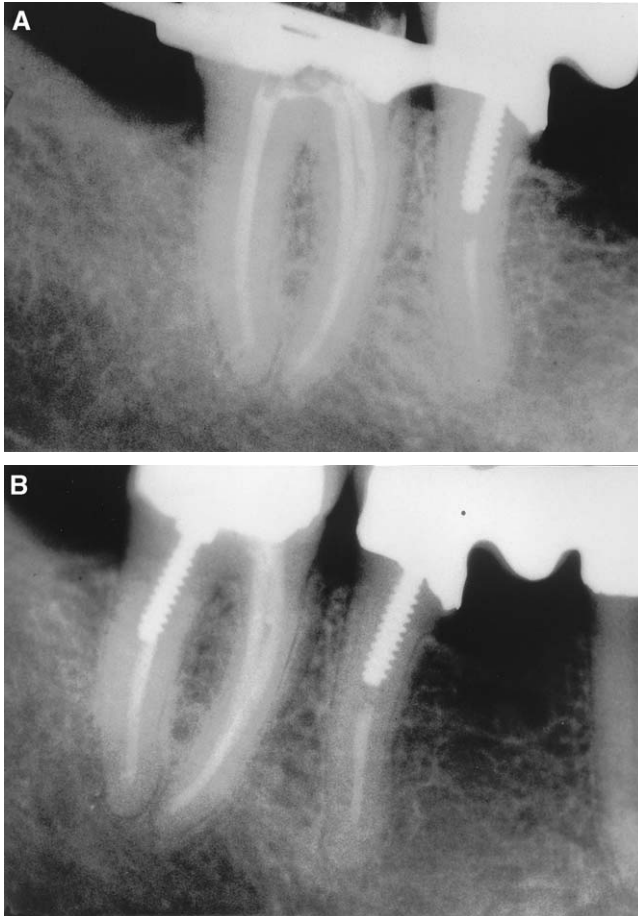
(A) Final fill radiograph (ThermaFil) of a mandibular second molar prepared with LightSpeed instruments using the “Zurich technique” (November 1994). MAR in the two mesial canals and one distal canal were sizes 42.5 and 50, respectively (case supplied by Dr. J. Zafran). (B) Fifteen-month follow-up radiograph of the mandibular second molar shown in Fig. 9A (February 1996; case supplied by Dr. J. Zafran).
